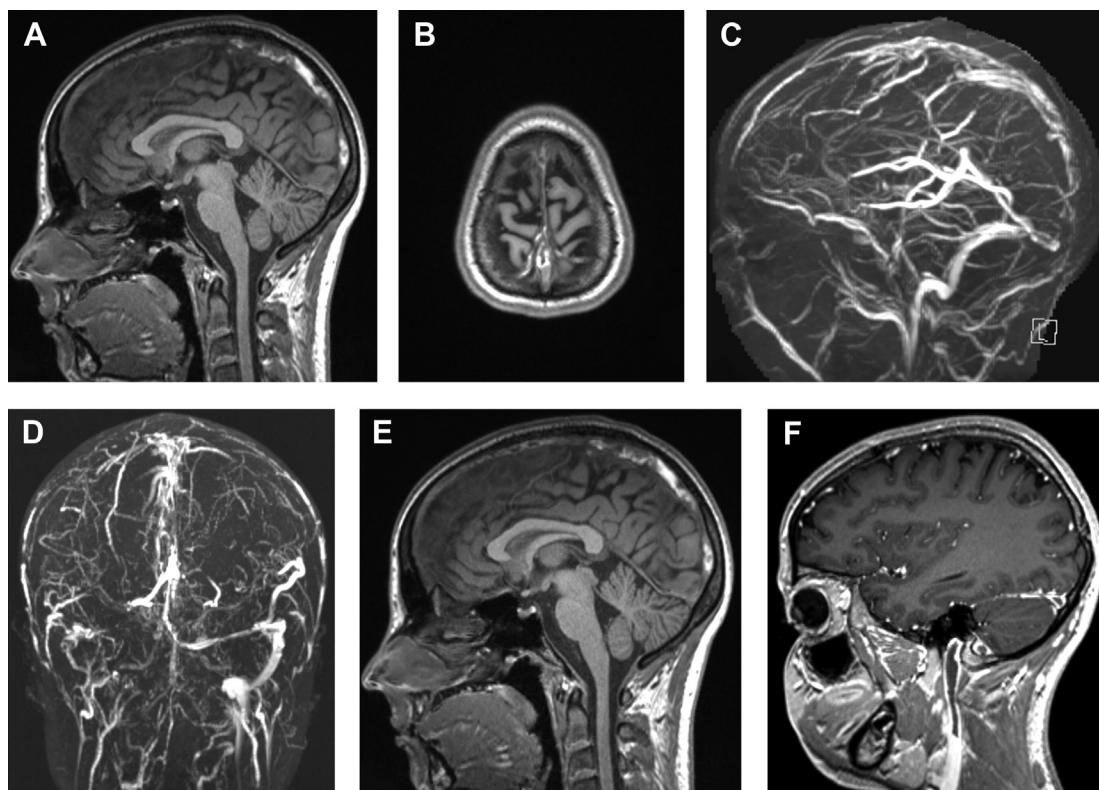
A 16-year-old girl with headache, ataxia, and papilledema due to CSVT 10 days after influenza infection. Sagittal and axial 3D T1-weighted gradient echo MR images (A, B) demonstrate extensive hyperintense thrombus within the superior sagittal sinus and tributary cortical veins. Sagittal and coronal maximum intensity projection 3-D reconstructions from time-of-flight MR venography (C, D) demonstrate loss of flow-related enhancement within the superior sagittal sinus and right transverse and sigmoid sinuses and upper internal jugular vein. Post-contrast sagittal 3D T1-weighted gradient echo (E, F) demonstrates filling defects in the same distribution. MR imaging showed findings of elevated intracranial pressure (not pictured).
